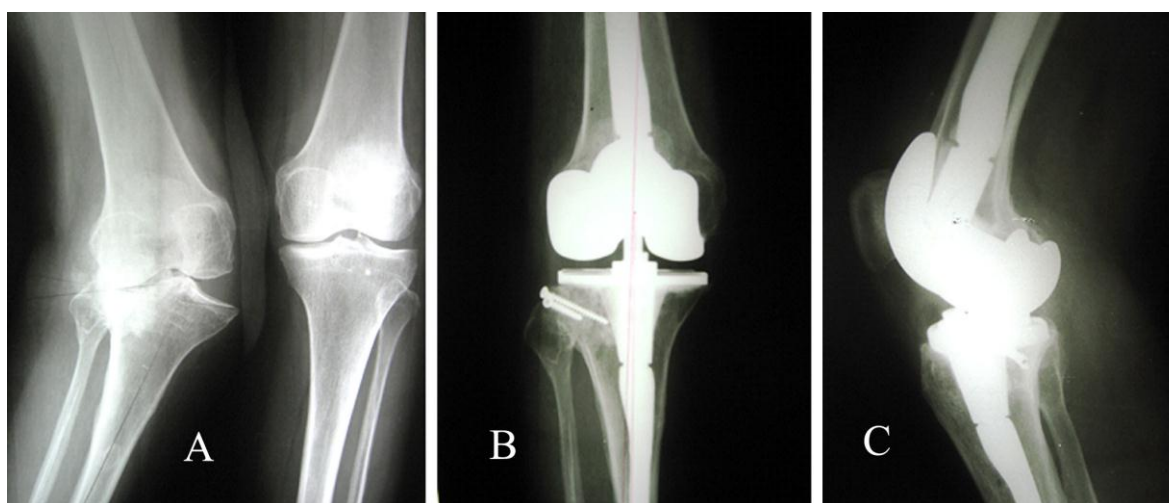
Preoperative (A) and postoperative (B, C) radiographs of a patient with severe valgus deformity replaced with LCKK prosthesis.
